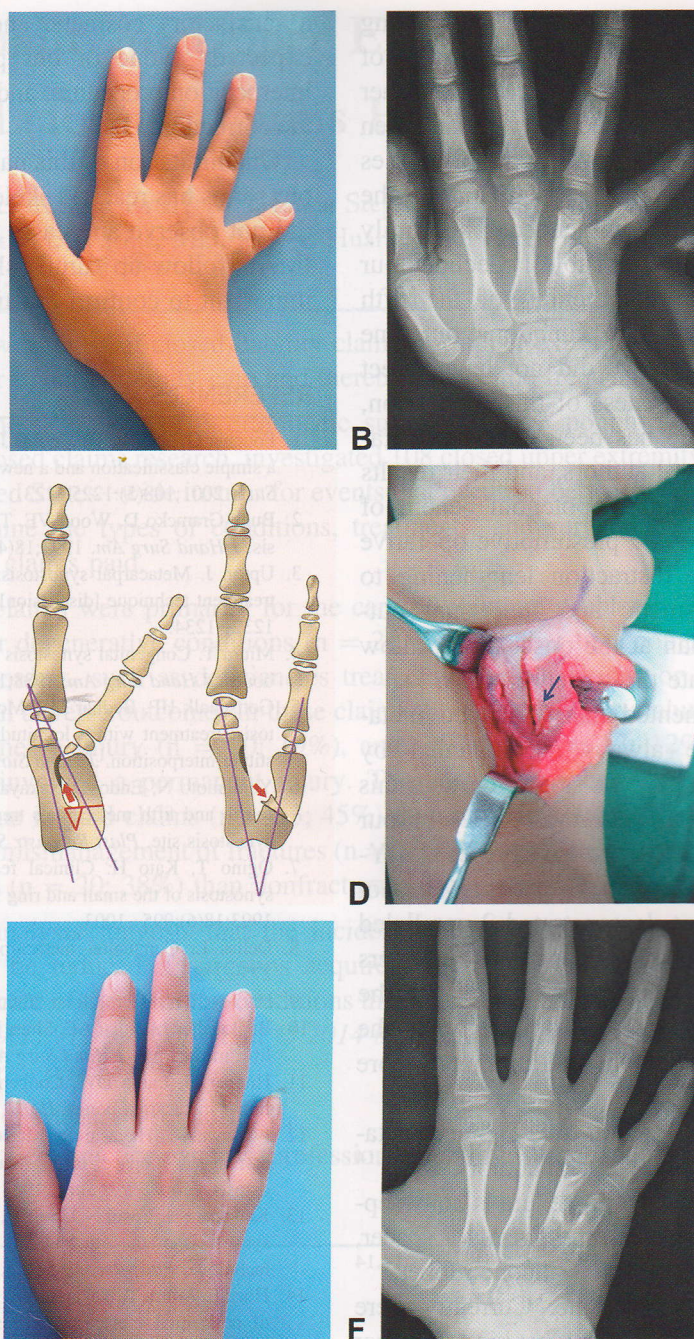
Our preferred treatment strategy for type B metacarpal synostosis. A Preoperative radiograph of the hand shows increased IMA between the ring and the little fingers. B Clinical photograph shows increased web space between the ring and the little fingers and bony prominence over the ulnar side of the palm. C The depiction of our preferred opening wedge adduction osteotomy for type B metacarpal synostosis. A triangular or trapezoidal bone graft (red arrows) was harvested from the synostosis site. Note the correction of the IMA depicted by the blue lines. D Opening wedge adduction osteotomy was accomplished with bone graft in position. E Postoperative radiograph shows the corrected IMA and restoration of normal alignment of the fifth ray. F Postoperative appearance with the deformity corrected.
